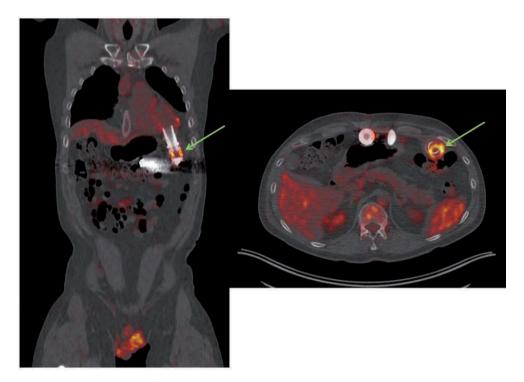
Case AI: ¹⁸F-FDG PET/CT images of a high FDG ring around the inflow cannula of the LVAD. Banded ring with high degree of accumulation in the connection part of the inflow cannula with the housing.
